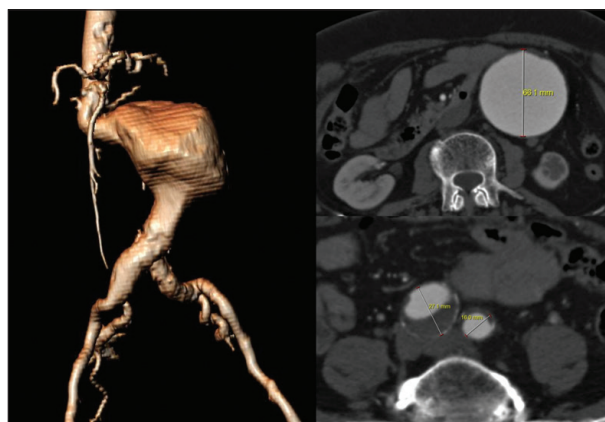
Pre-operative CTA.
